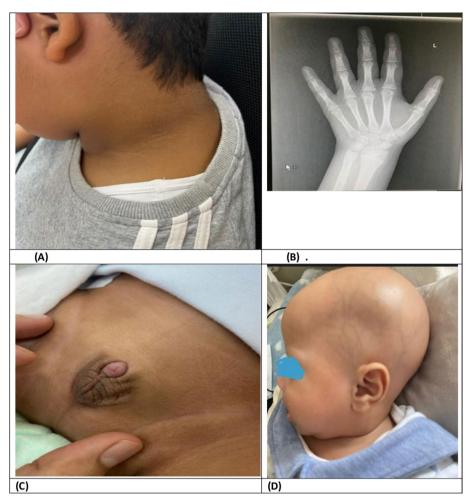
A 9-year-old obese boy with acanthosis nigricans (A); X-ray hand of a 7-year-old female with precocious puberty showing advanced bone age (B); a 1-month patient presented with ambiguous genitalia showing closed labia that includes folds resemble a scrotum and enlarged clitoris which resemble a penis (C); a 3-month-old presented with hypocalcemia and alopecia diagnosed as type 2 vitamin D-dependent rickets (D)
